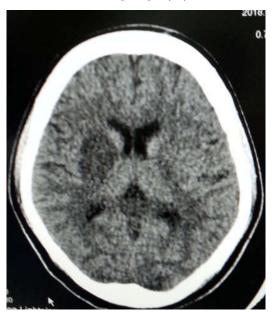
CT brain axial view showing hypodensity in right basal ganglia
